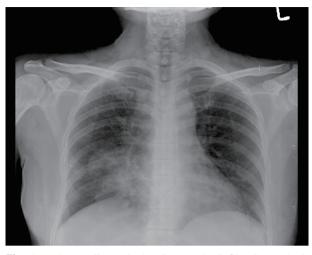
A chest radiograph showing patchy infiltration at both lower lung lobes (Bronchiectasis)
